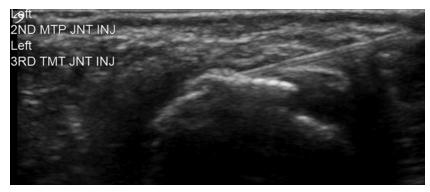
Sonographically guided second metatarsophalangeal joint injection, long axis to joint, needle in plane with transducer. Left, medial; right, lateral.
